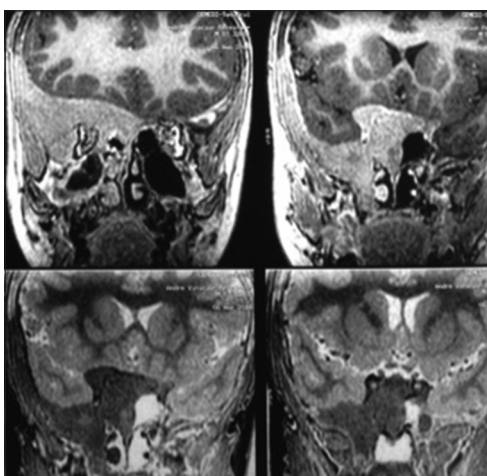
Magnetic resonance imaging: High sign at T1 and low sign at T2 sequences show the fibrous dysplastic pattern
